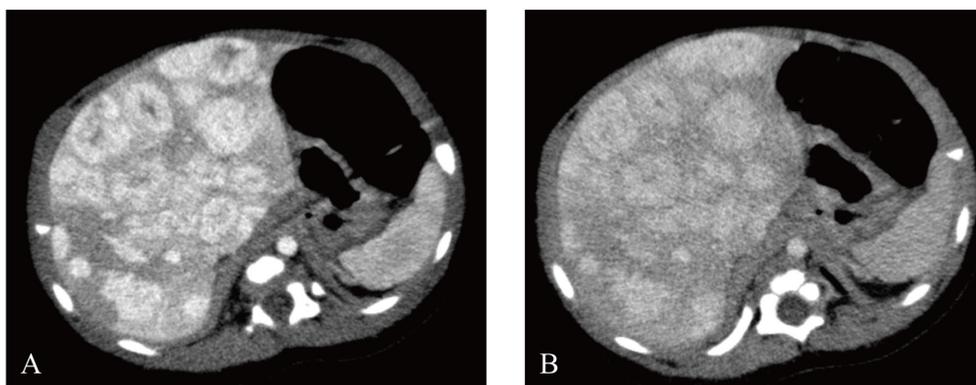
Pretreatment contrast-enhanced computed tomography (CT) of the liver
